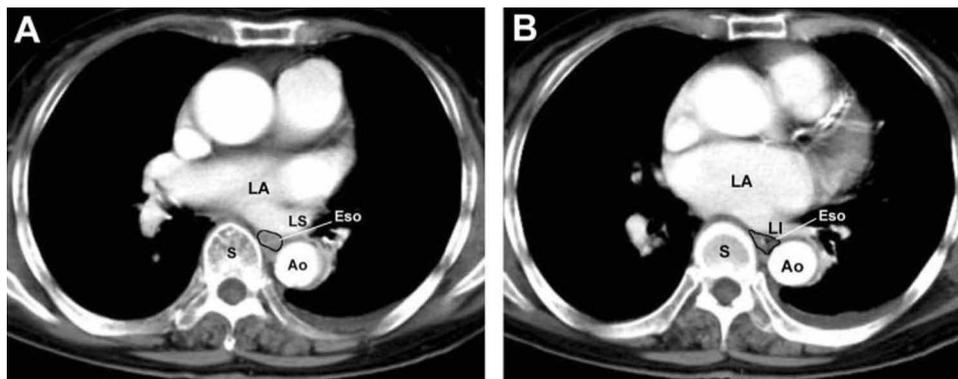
Axial CT images of a patient with a type 1 esophageal route (the distance to the LIPV is shorter than that to the RIPV). *Left, A:* At the LSPV level, the location of the esophagus (enhanced border) is behind the LA and LSPV, between the thoracic spine (S) and descending aorta. *Right, B:* At the LIPV level, the esophagus is crowded into a space surrounded by the LIPV, spine, and descending aorta. Thus, it becomes triangular. Eso = esophagus; LS = left superior; LI = left inferior; see Figure 2 for expansion of abbreviation.
